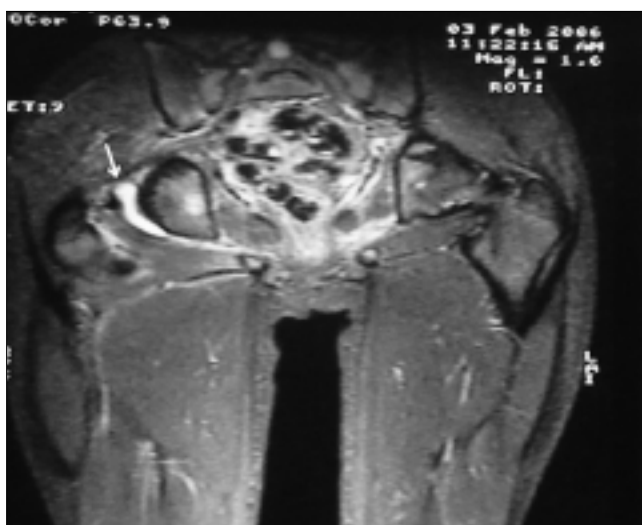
Magnetic resonance imaging of the right hip
